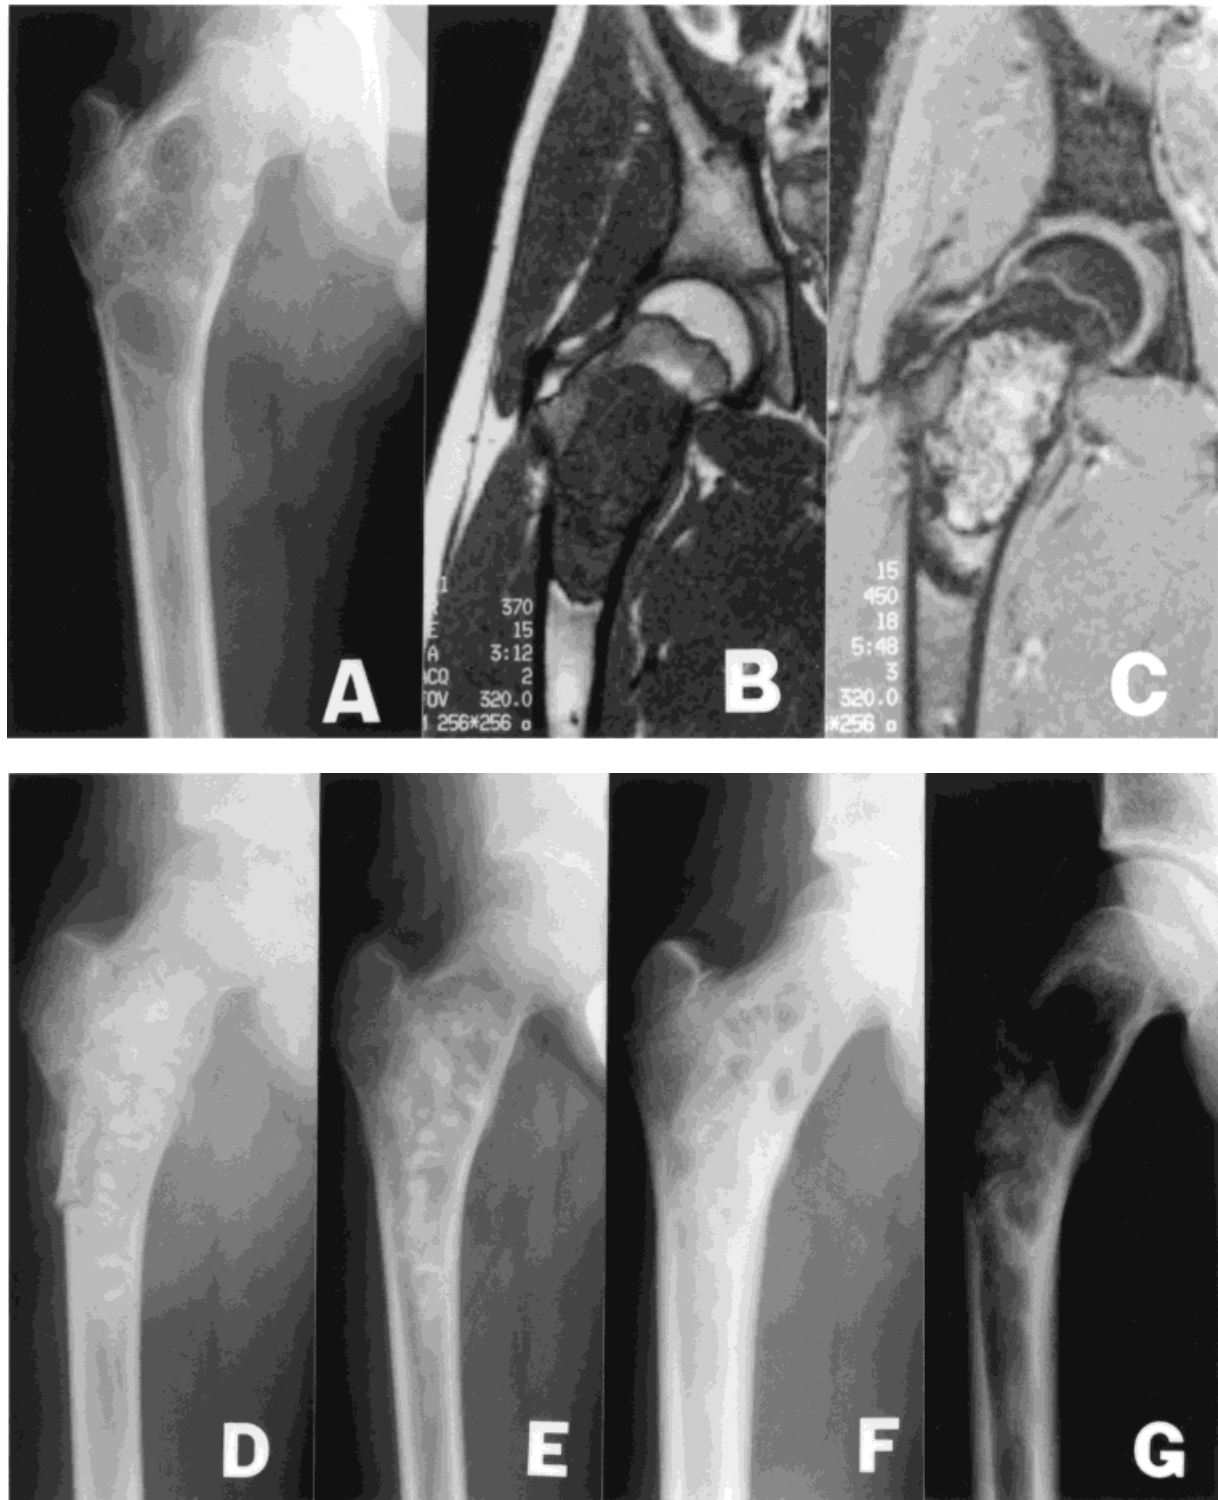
Routine radiograph (A) of a circumscribed lesion of the right hip in Patient 9 after biopsy. Less than one-fourth of the entire femur and only the medial cortex are involved. The coronal MR images before biopsy, T1 weighted (B) and T2 weighted, fast spin echo sequence (C) show an inhomogeneous lesion without clear expansion. The postoperative follow-up is shown in (D) 0 month; (E) 6 months; (F) 24 months; and (G) 60 months. There is a gradual resorption of the bone graft but with a recurrence of the fibrous dysplasia in the femoral neck. So far the patient is asymptomatic and no treatment is planned.
